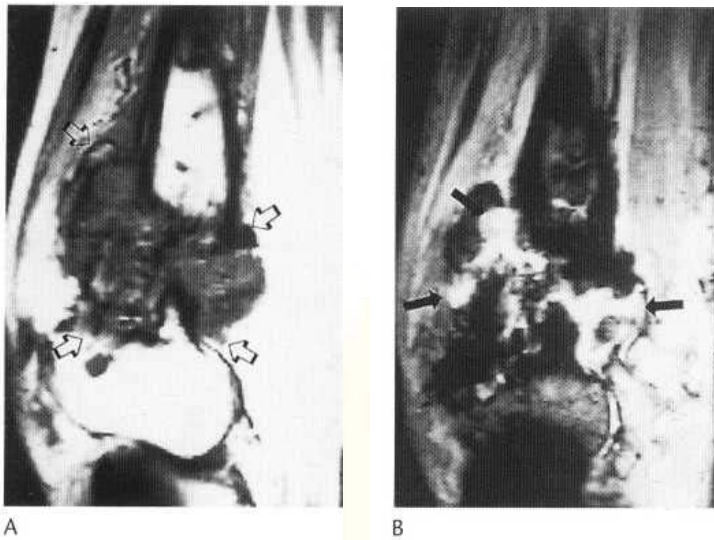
(A) MRI scan demonstrates tissue of mixed signal intensity in the fracture gap of non-union of the distal femur (arrows) on T_1 -weighted images. (B) Areas of increased signal intensity are shown on T_2 -weighted images (dark arrows), indicating foci of infection.
